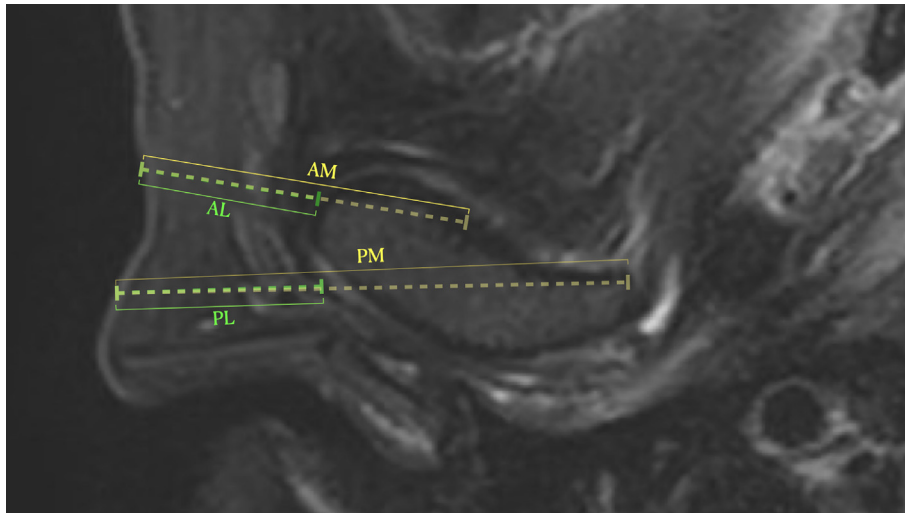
Axial magnetic resonance image section showing the anterior-medial (AM), anterior-lateral (AL), posterior-medial (PM), and posterior-lateral (PL) distances for temporomandibular joint arthrocentesis needle placement.
